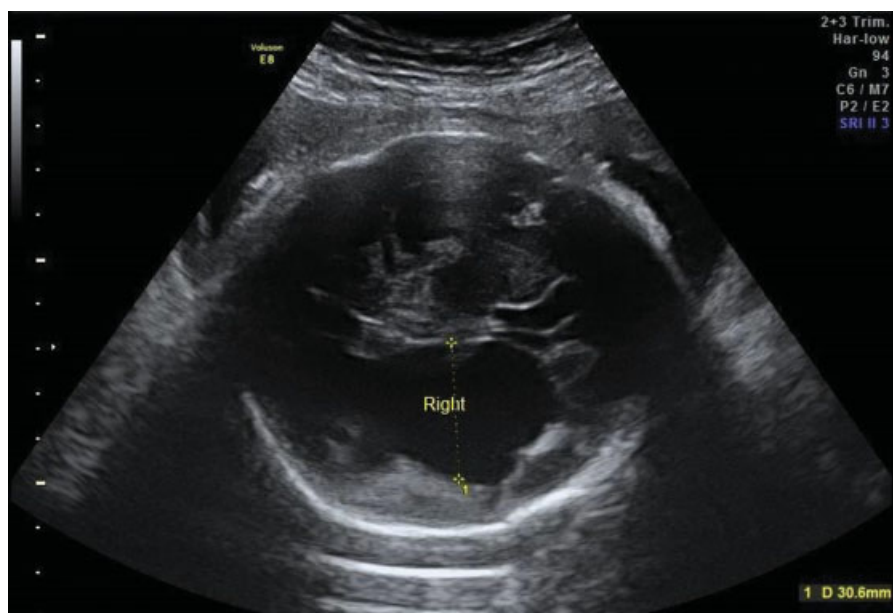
Antenatal cranial ultrasound image in the transverse plane at a gestational age of 33⁺² weeks, showing severe, irregular dilatation of the right lateral ventricle, and a normally sized left ventricle, suspect for a large right-sided porencephalic cyst.
